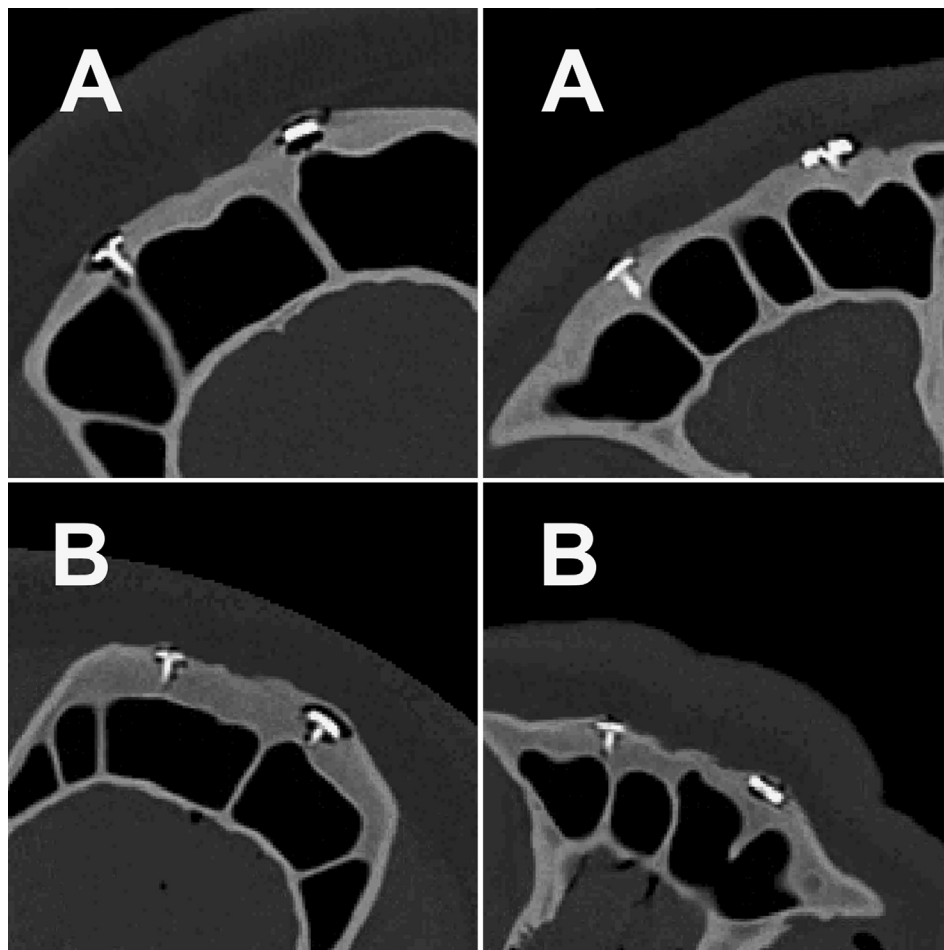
Computed tomogram (CT) of minipig with magnesium-coated plate/screws after euthanasia at 12 weeks after surgery (A) and 24 weeks after surgery (B), through the topmost screw a1 (left) and the bottommost screw a8 (right).
